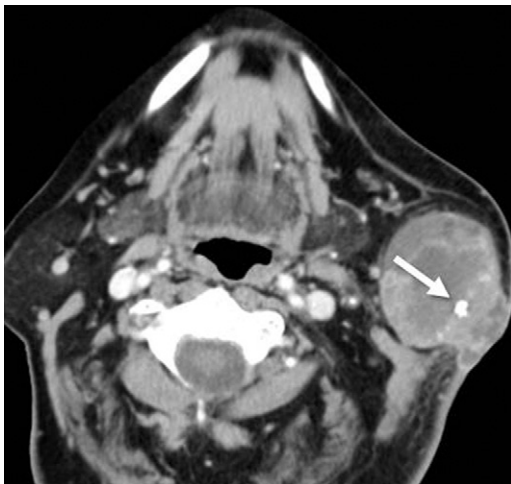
Carcinoma ex pleomorphic adenoma. Axial contrast-enhanced CT shows a heterogeneously enhancing mass within the superficial left parotid gland. The mass demonstrates well-defined borders except for the posterolateral margin, consistent with extracapsular extension to the skin. A dystrophic calcification is present (arrow).
